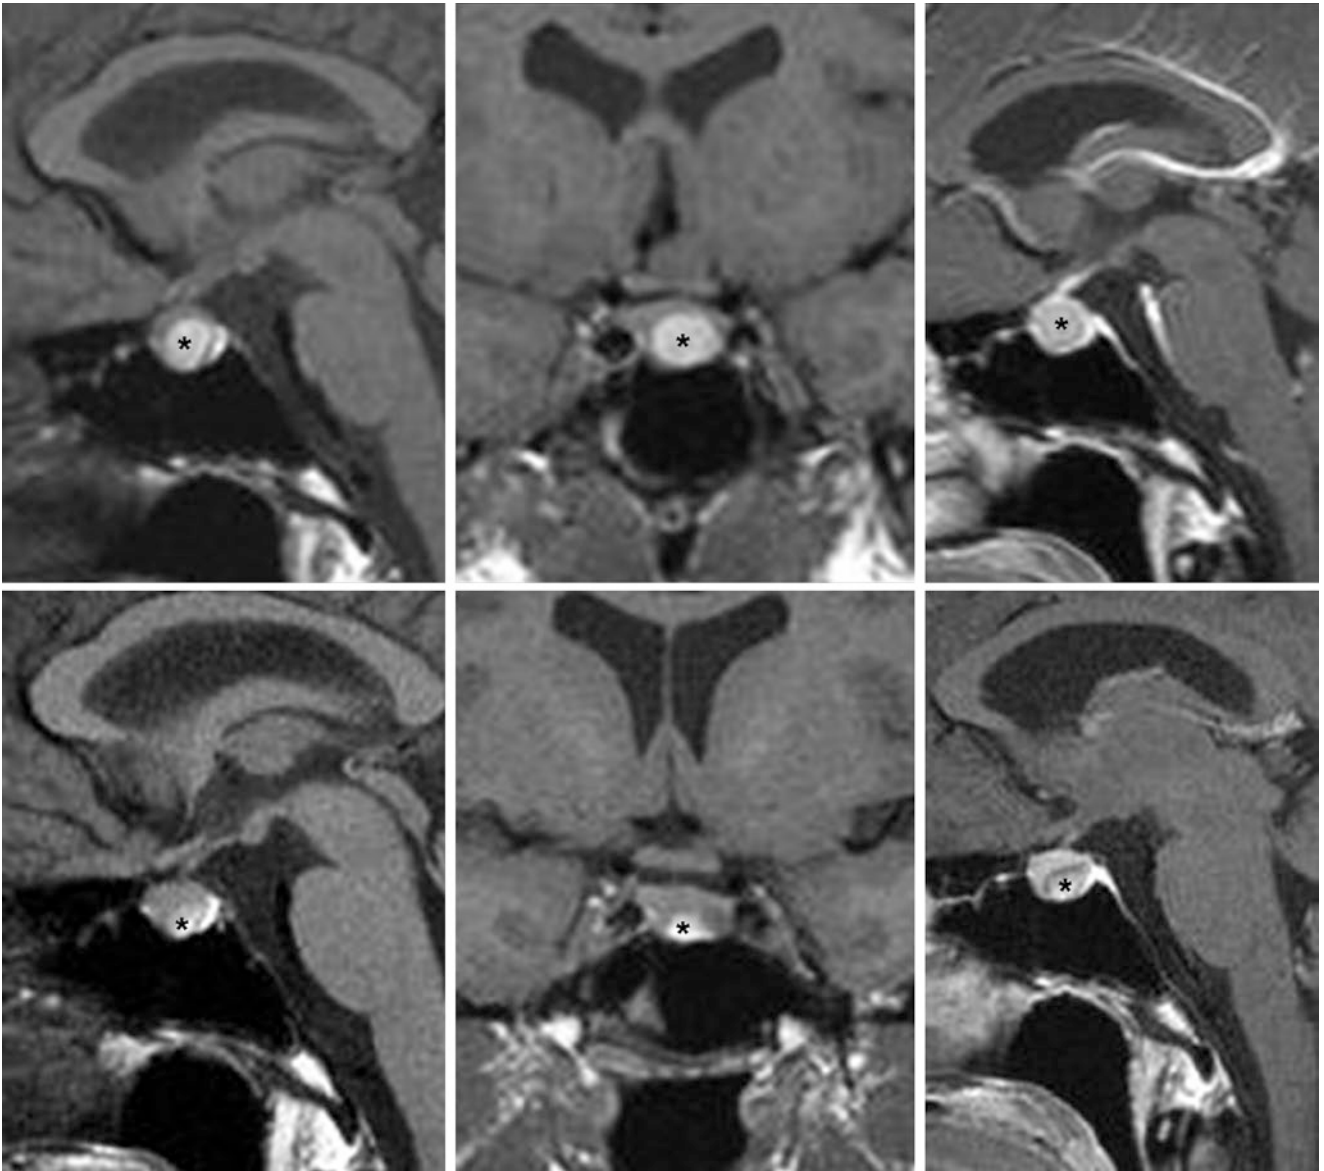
Comparison case of macroadenoma with hemorrhage. A 23-year-old female patient with prolactinemia had an 11-mm T1-bright pituitary lesion on MRI (*), on noncontrast sagittal (*top left*) and coronal (*top middle*) T1WIs that was isointense to the surrounding glandular tissue on postcontrast sagittal T1WI (*top right*). The radiologist initially
